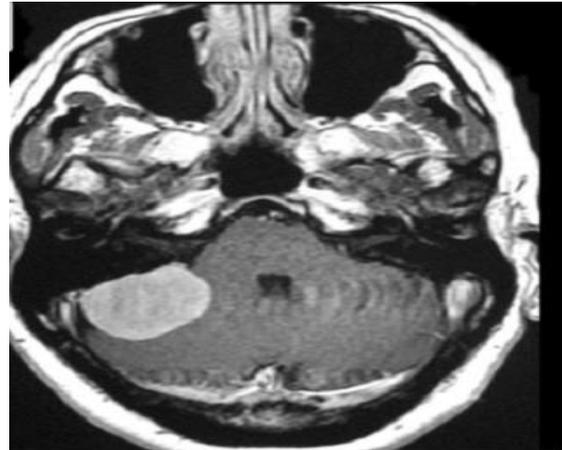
T2 weighted MRI Scan shows high signal intensity with postcontrast administration in the cerebellopontine angle.
